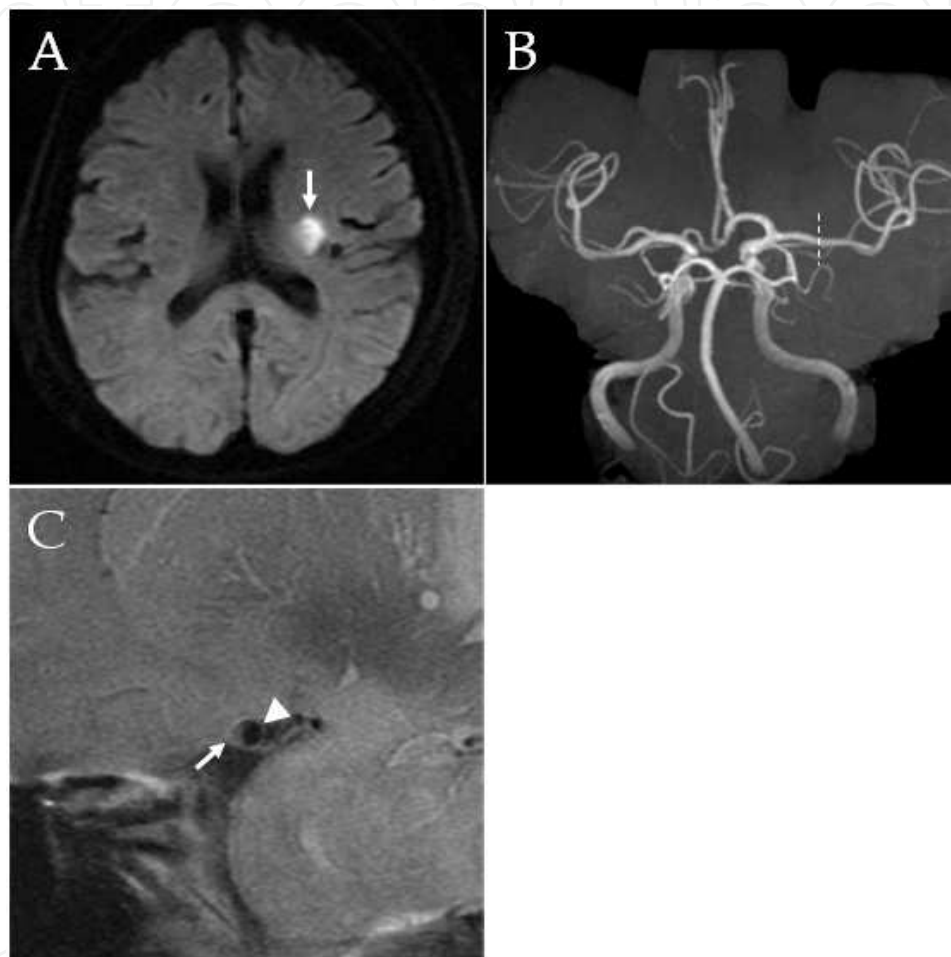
Middle cerebral artery plaque which cannot be detected by magnetic resonance angiography (modified from Niizuma et al., 2008). A: Axial Diffusion-weighted image demonstrating a high-intensity lesion, 12 mm in diameter, in the left corona radiata (arrow). B: Magnetic resonance angiography showing no evidence of atherosclerosis. C: High-resolution magnetic resonance image perpendicular to the left MCA, at the level of the dotted line in B (TR/TE 2800/50.8, FOV 12 cm \times 12 cm, matrix size 512 \times 256, slice thickness 2 mm, interslice gap 0.3 mm, NEX 5), presenting the lumen of the left middle cerebral artery (arrow) and plaque on the vessel wall (arrowhead), despite the apparently normal magnetic resonance angiography.
